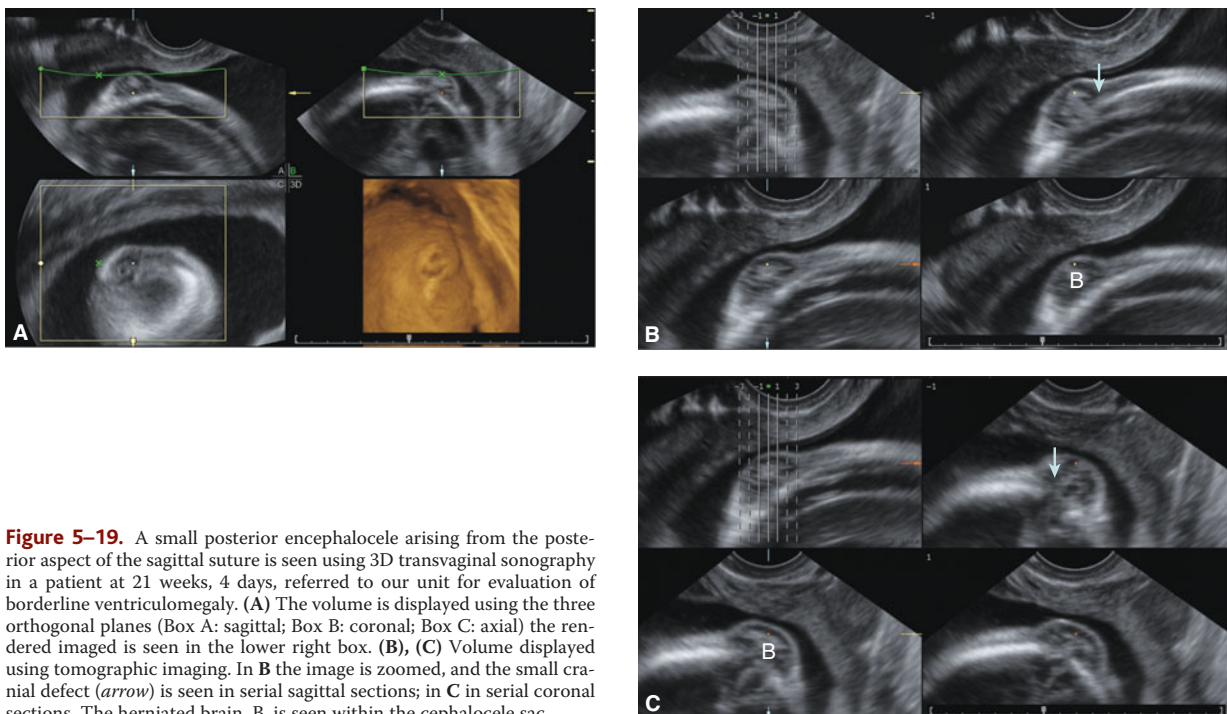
A small posterior encephalocele arising from the posterior aspect of the sagittal suture is seen using 3D transvaginal sonography in a patient at 21 weeks, 4 days, referred to our unit for evaluation of borderline ventriculomegaly. (A) The volume is displayed using the three orthogonal planes (Box A: sagittal; Box B: coronal; Box C: axial) the rendered image is seen in the lower right box. (B), (C) Volume displayed using tomographic imaging. In B the image is zoomed, and the small cranial defect (arrow) is seen in serial sagittal sections; in C in serial coronal sections. The herniated brain, B, is seen within the cephalocele sac.
